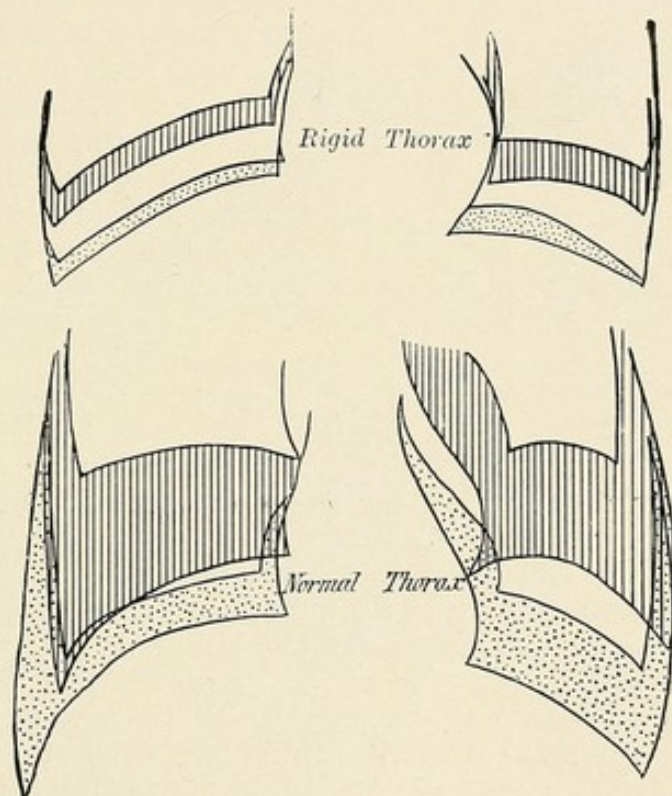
Mobility of the diaphragm with rigid and with normal thorax. Distance covered in a recumbent position ||||, in an upright position : : : : X-ray pictures by VON DEN VELDEN.
